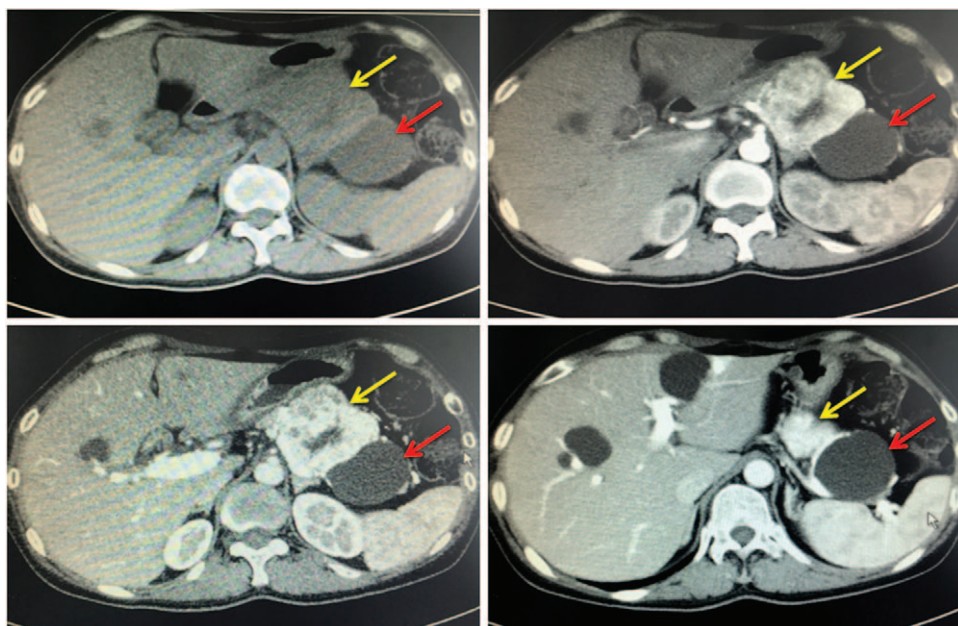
Computed tomography showed a cystic and solid mass located in the pancreatic tail. Yellow arrow: a solid lesion. Red arrow: a cystic lesion.
